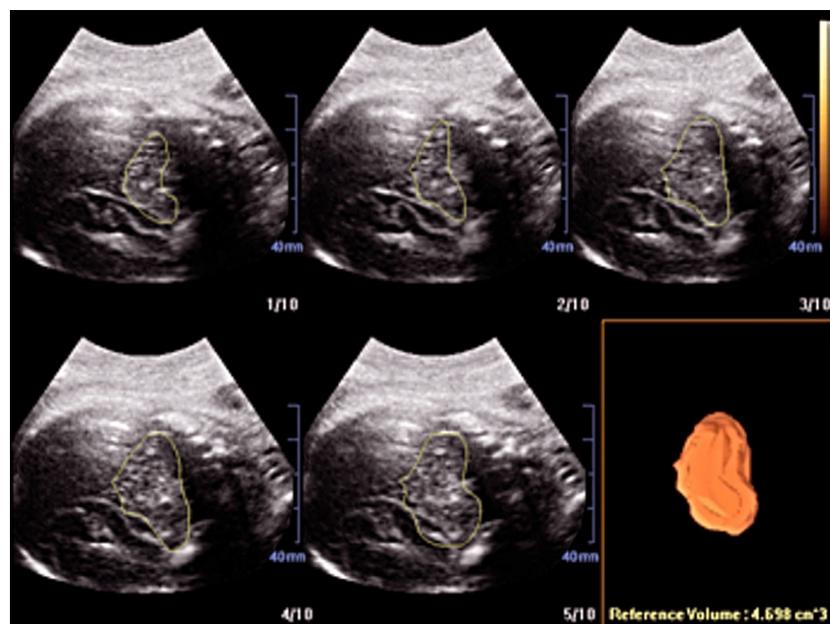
Fetal neurosonogram. Fetal cerebellum volume was calculated at 20 wk of gestation using extended imaging virtual organ computer-aided analysis (XI VOCAL) with 10 sequential planes.
